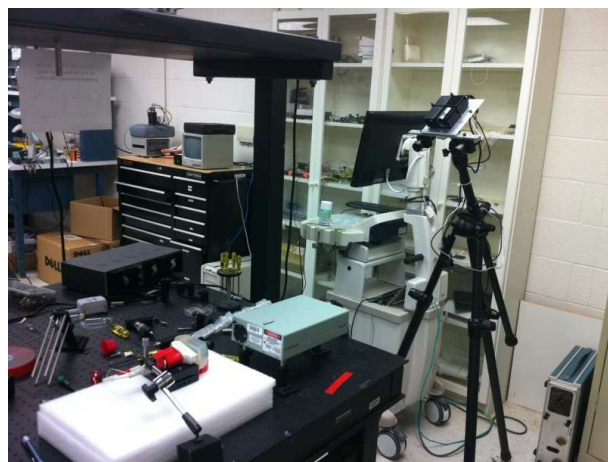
Ultrasound-photoacoustic imaging system combined with a stereocamera.
